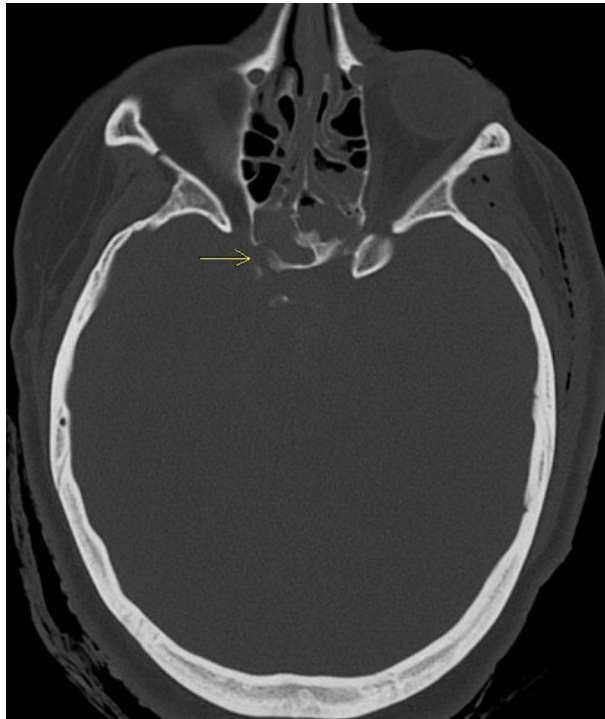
Axial view of the head CT. (Yellow arrow: right-sided lateral sphenoid wall fracture due to force of penetrating trauma).
